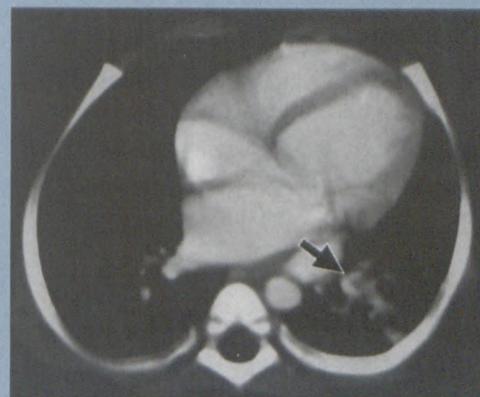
CT scan of the chest after intravenous contrast administration demonstrates a brightly enhancing conglomerate of vessels (arrow)
